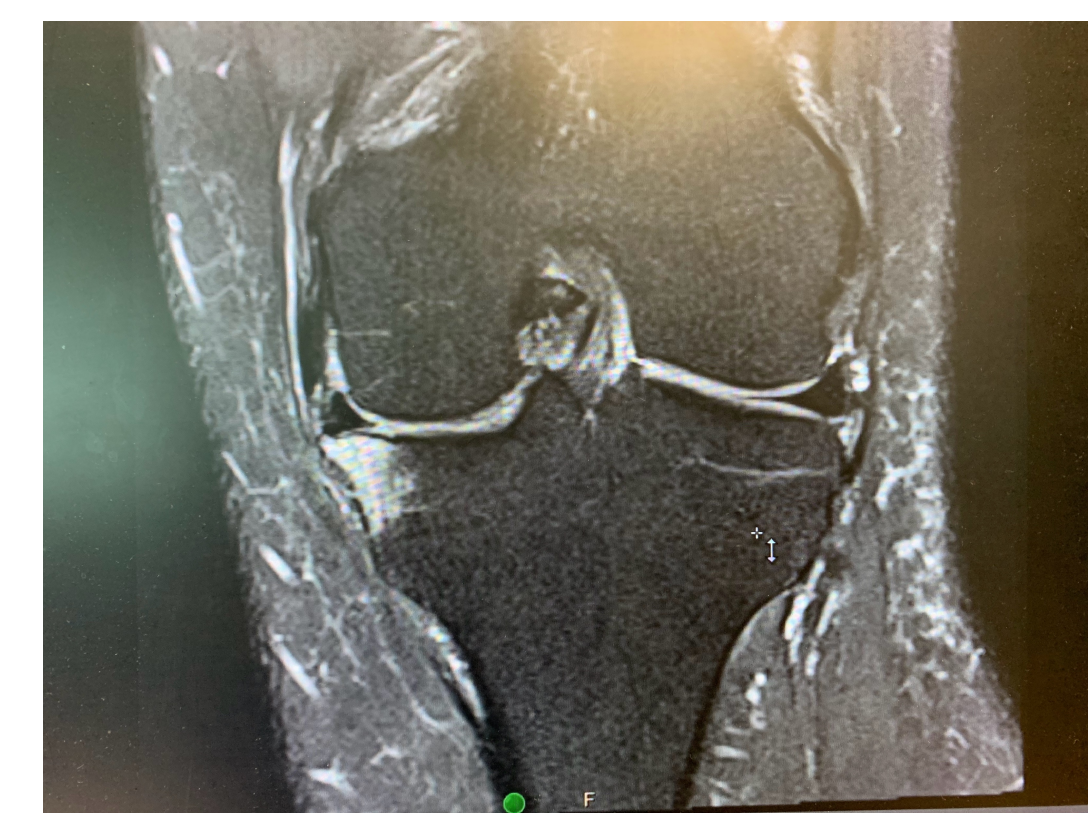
MRI image of BME from AP View- Case 1
